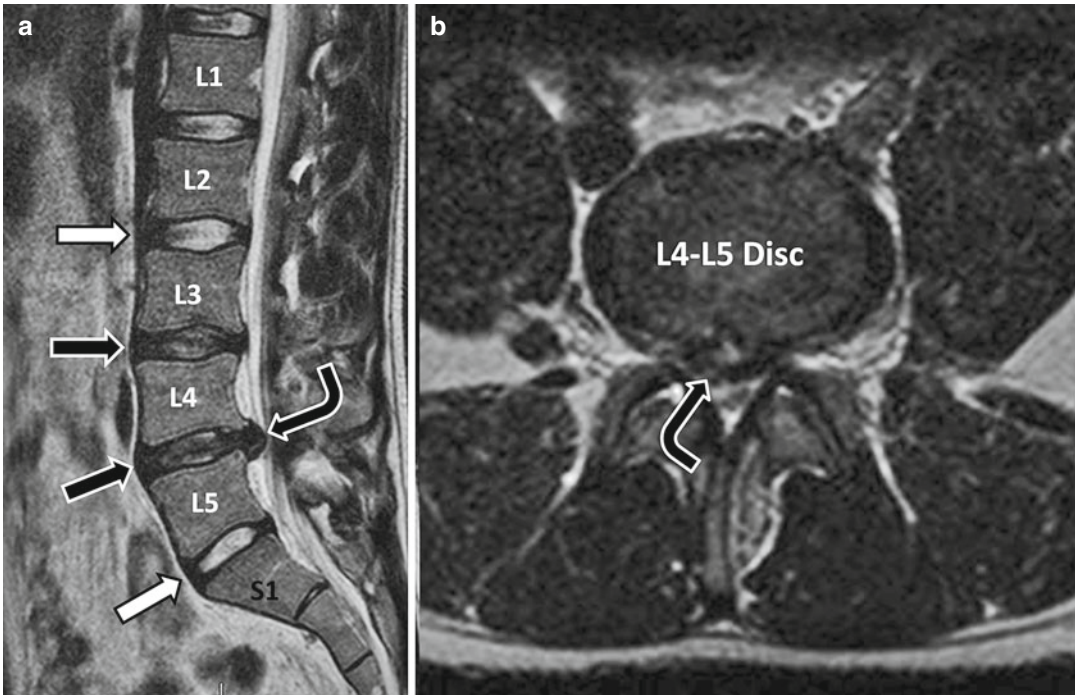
A 30-year-old man with acute right-sided radicular pain. (a) Sagittal T2-weighted MRI shows disk desiccation at L3–4 and L4–5 (*white arrows*) compared to normally hydrated disks L2–3 and L5–S1 (*black arrows*). Large disk bulge is narrowing the right paracentral canal
